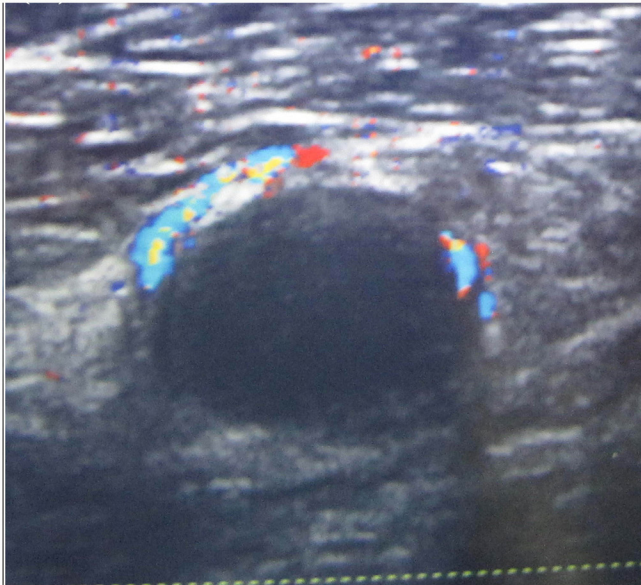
Doppler ultrasound examination showing an avascular hypoechoic mass and vascularity with blood flowing around the mass.
